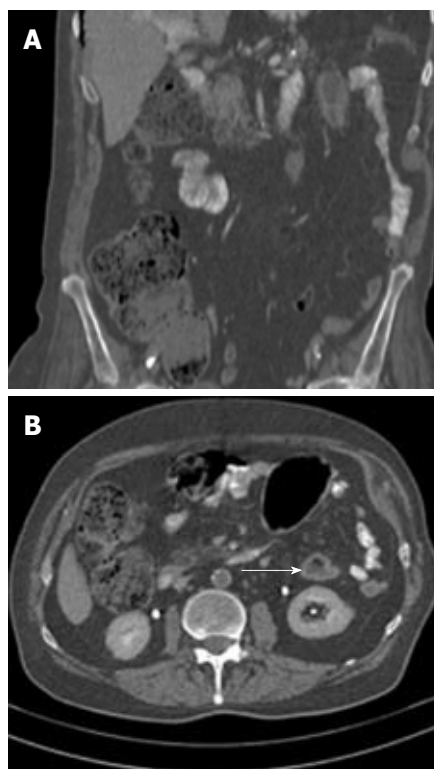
Contrast-enhanced abdominal computed tomography scans suggesting segmental colitis involving the splenic flexure and the descending colon. A: Coronal sections with zones of mural thickening of the colon just below the splenic flexure and a long and narrow axial stenosis of the descending colon; B: Sagittal sections showing (arrow) the “double halo” sign, a tomographic equivalent of the classic “thumbprinting” that is observed in barium enemas.
